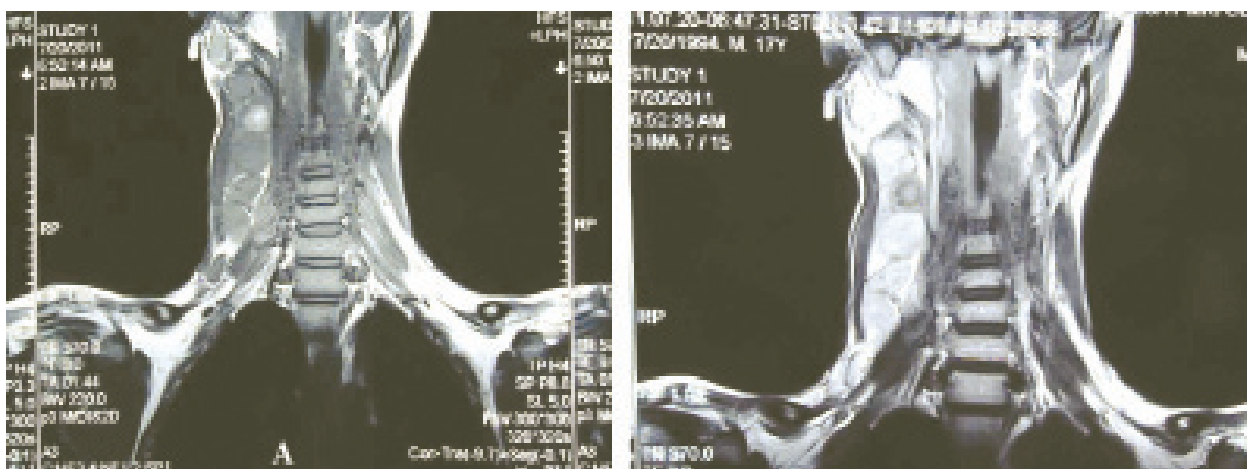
A) MRI without contrast of the neck revealed an isointense lobulated mass in the right side and a hyperintense focus probably due to hemorrhage. B) MRI with contrast showed enhancement of the mass
